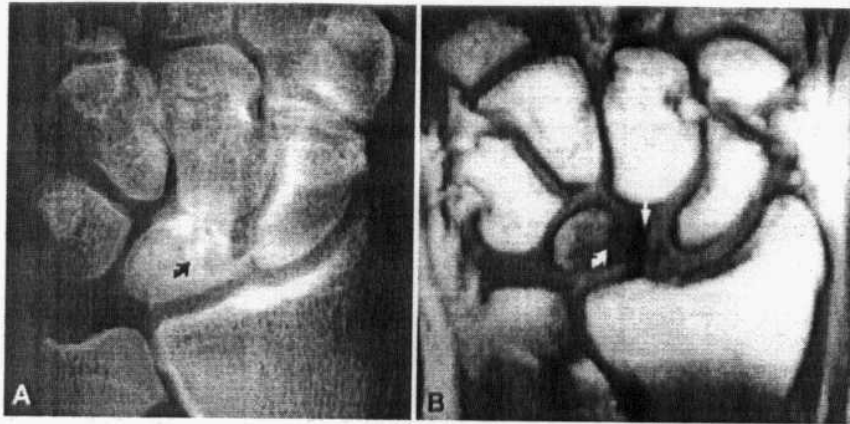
(A) An anteroposterior radiograph shows lunate collapse (curved arrow) and proximal migration of the capitate in stage III Kienböck's disease. (B) A T1-weighted coronal image better depicts necrotic marrow (curved arrow) and lunate collapse in the radial border (straight arrow) (Quoted from Stoller and Brody, 1997).
